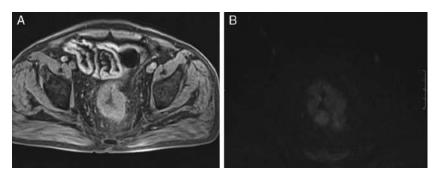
(A) High definition axial T1-weighted MRI post-Gd clearly depicts rectal tumor, with transmural stranding in mesorectal fat. (B) Axial diffusion-weighted at the same level shows hyperintensity of the rectal wall involved by tumor.
